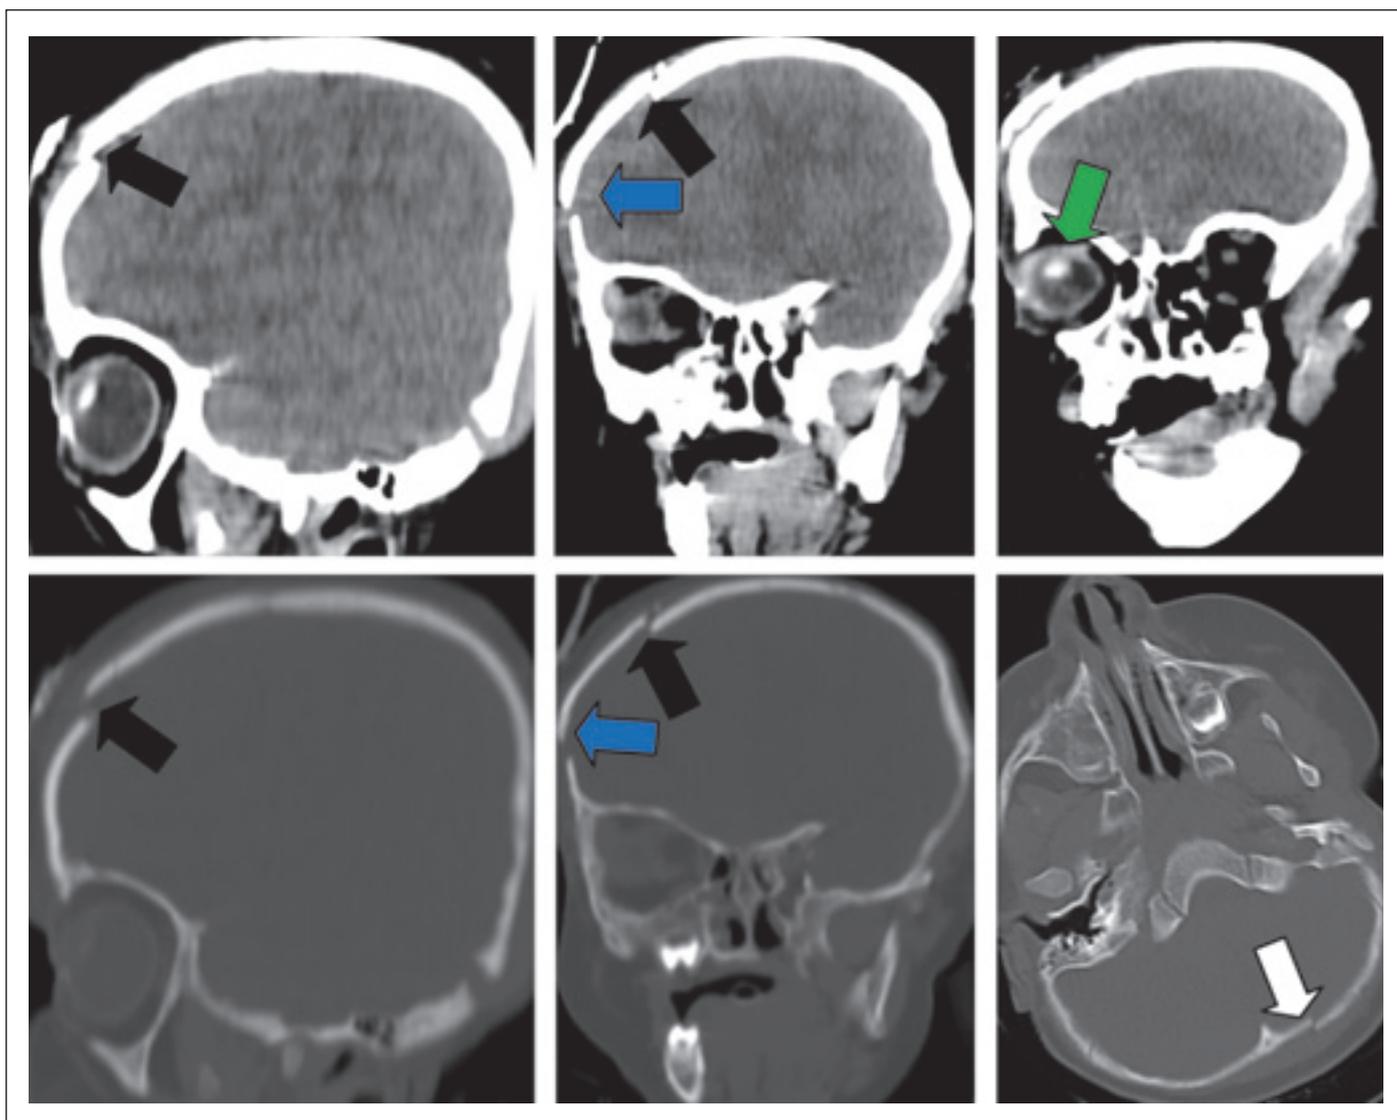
Pre-operative CT images of the same anatomical level displayed in the brain (tissue) window (upper row) and bone window (lower row). In each row, images are shown from left to right as sagittal, coronal, and axial sections. The black arrow indicates the displaced frontal fracture, the blue arrow points to the temporal fracture, the white arrow shows the occipital fracture line, and the green arrow marks the IV cranial nerve involvement.
